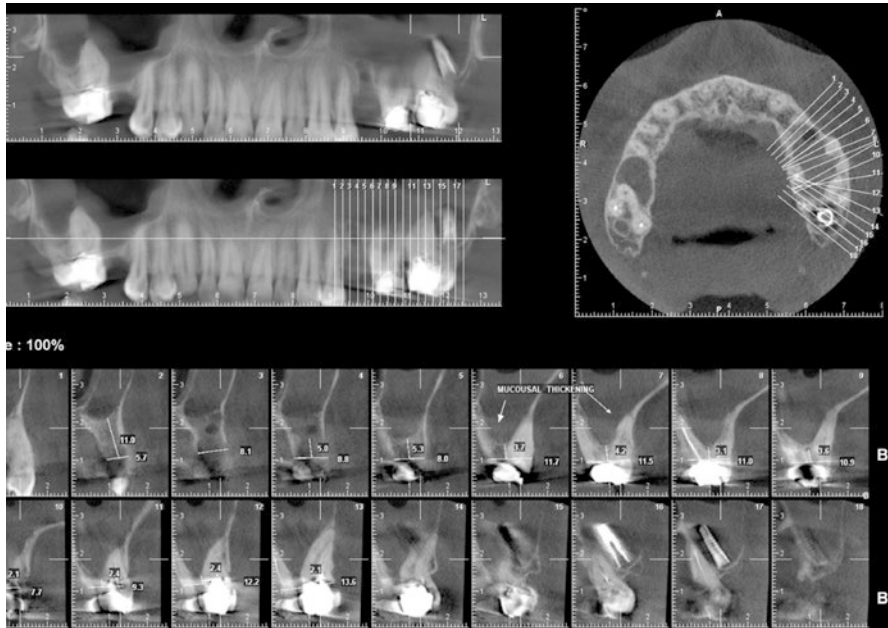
Cone-beam CT scan of a patient with an implant inserted at the left upper second premolar socket displaced into the left maxillary sinus. Without a CBCT evaluation, estimating the correct position of the displaced implant would have been very difficult. Note the Oro-antral fistula at the implantation site, mucosal thickening in the right antrum, and air-fluid levels in the left antrum
